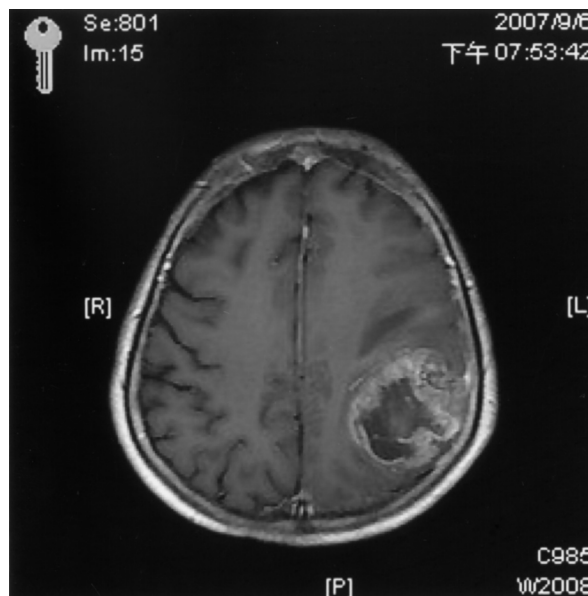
Brain MRI showing a large lobulated mass in the left temporoparietal lobes with perifocal edema.
